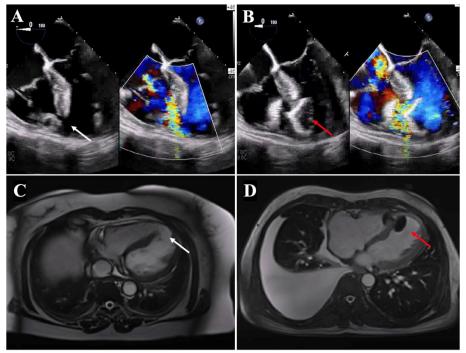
Baseline and after percutaneous closure of a PIVSR imaging by color-compare TEE (A and B) and cardiac magnetic resonance imaging (C and D). The defect was located in the apical septum (white arrow). The occluder is well-seated with minimal residual shunt (red arrow). PIVSR, Post-infarction ventricular septal rupture; TEE, Trans-esophageal echocardiography
